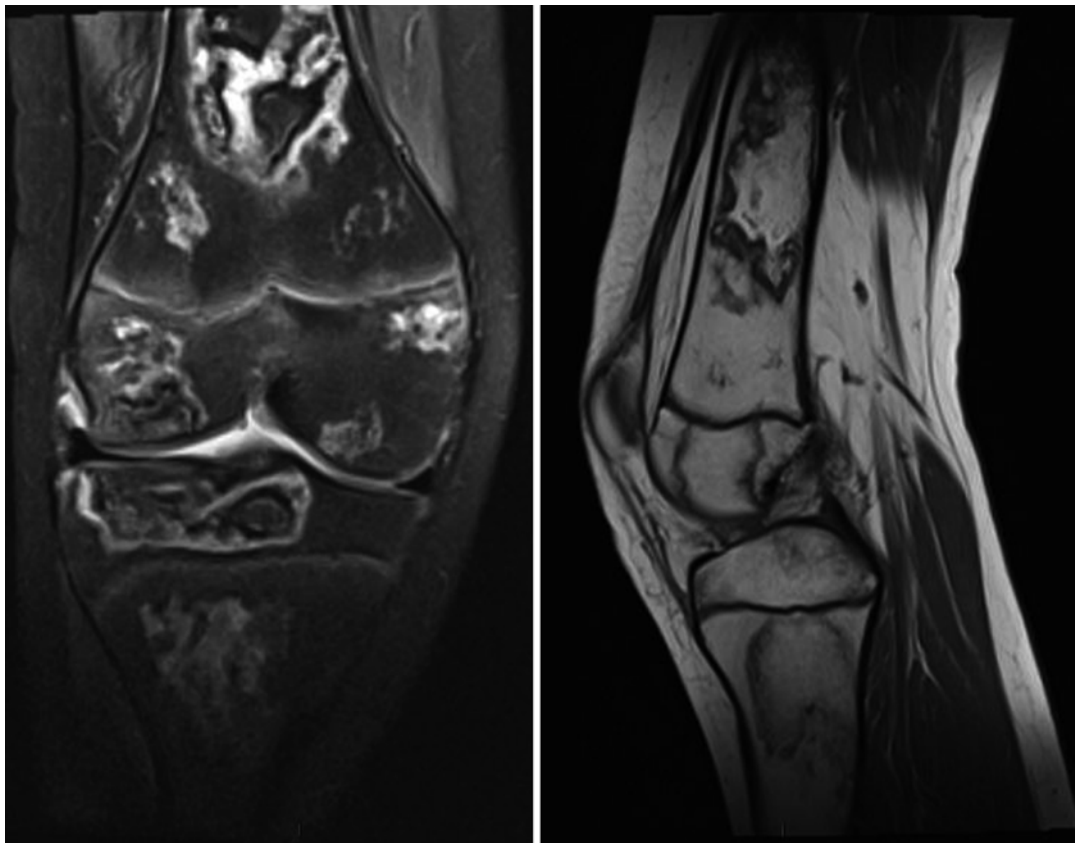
MRI showing bone infarcts in a patient treated with chemotherapy and steroids for leukemia
